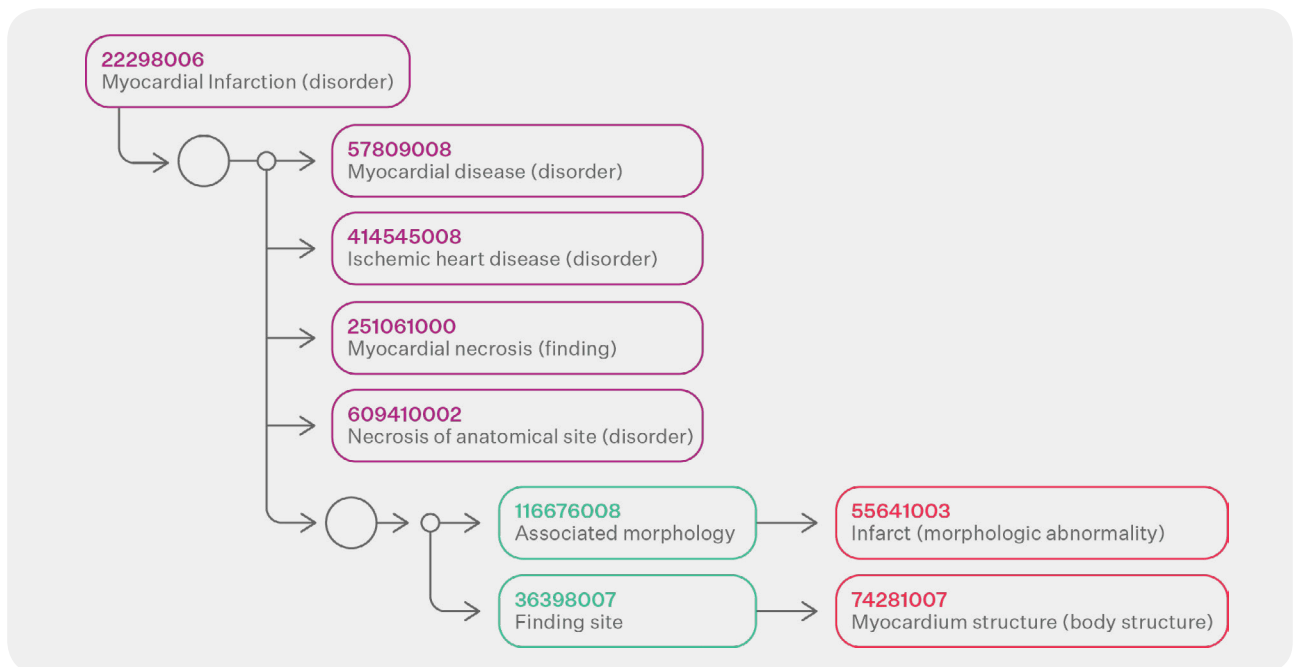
SNOMED-CT Structure
